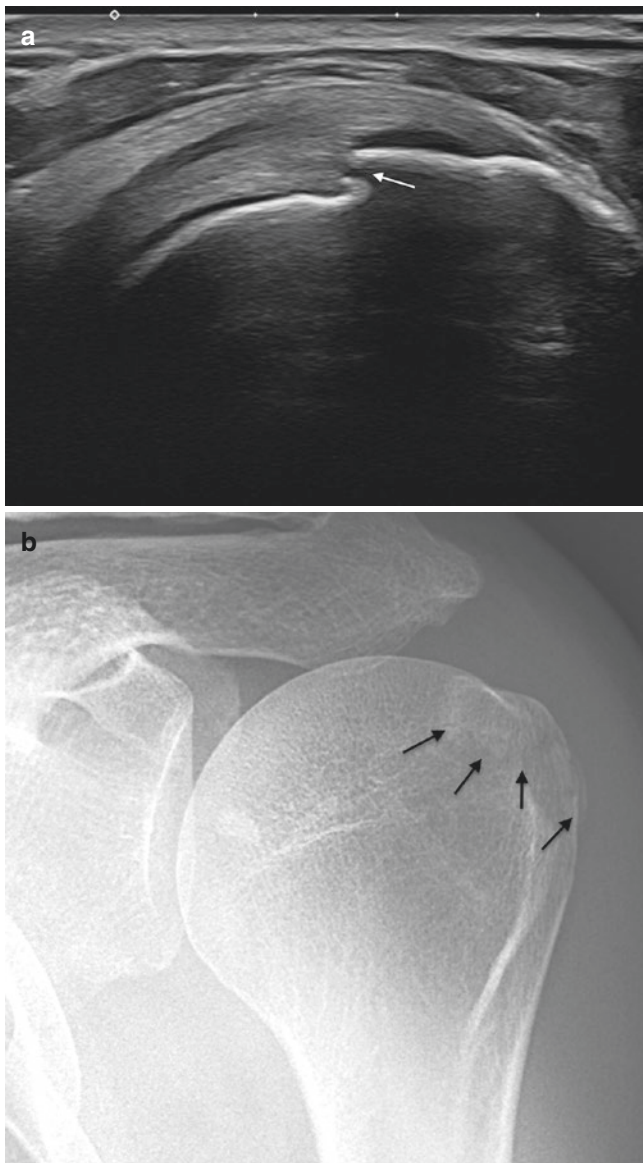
A 45-year-old male with a request of US to rule out rotator cuff lesion after indirect trauma; (a) US of the shoulder shows discontinuity of the cortical bone of the greater tuberosity (arrow); (b) AP radiograph performed later demonstrates the small non-displaced fracture (arrows)
